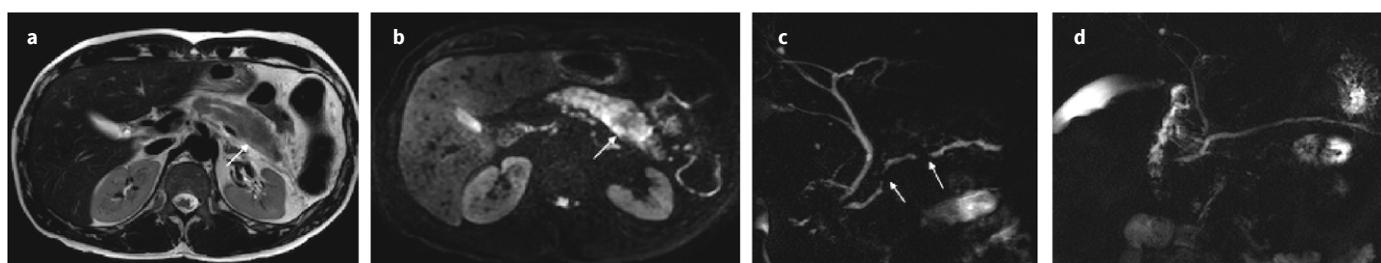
Autoimmune pancreatitis. a | T2-weighted image shows focal pancreatic gland enlargement (arrow) with mild peripancreatic infiltration. b | Irregular hypersignal in DWI (arrow). c | MRCP shows multifocal duct narrowing (arrows) and diffuse irregularity suggesting autoimmune pancreatitis. d | Complete resolution of abnormalities of the duct after steroid treatment.
